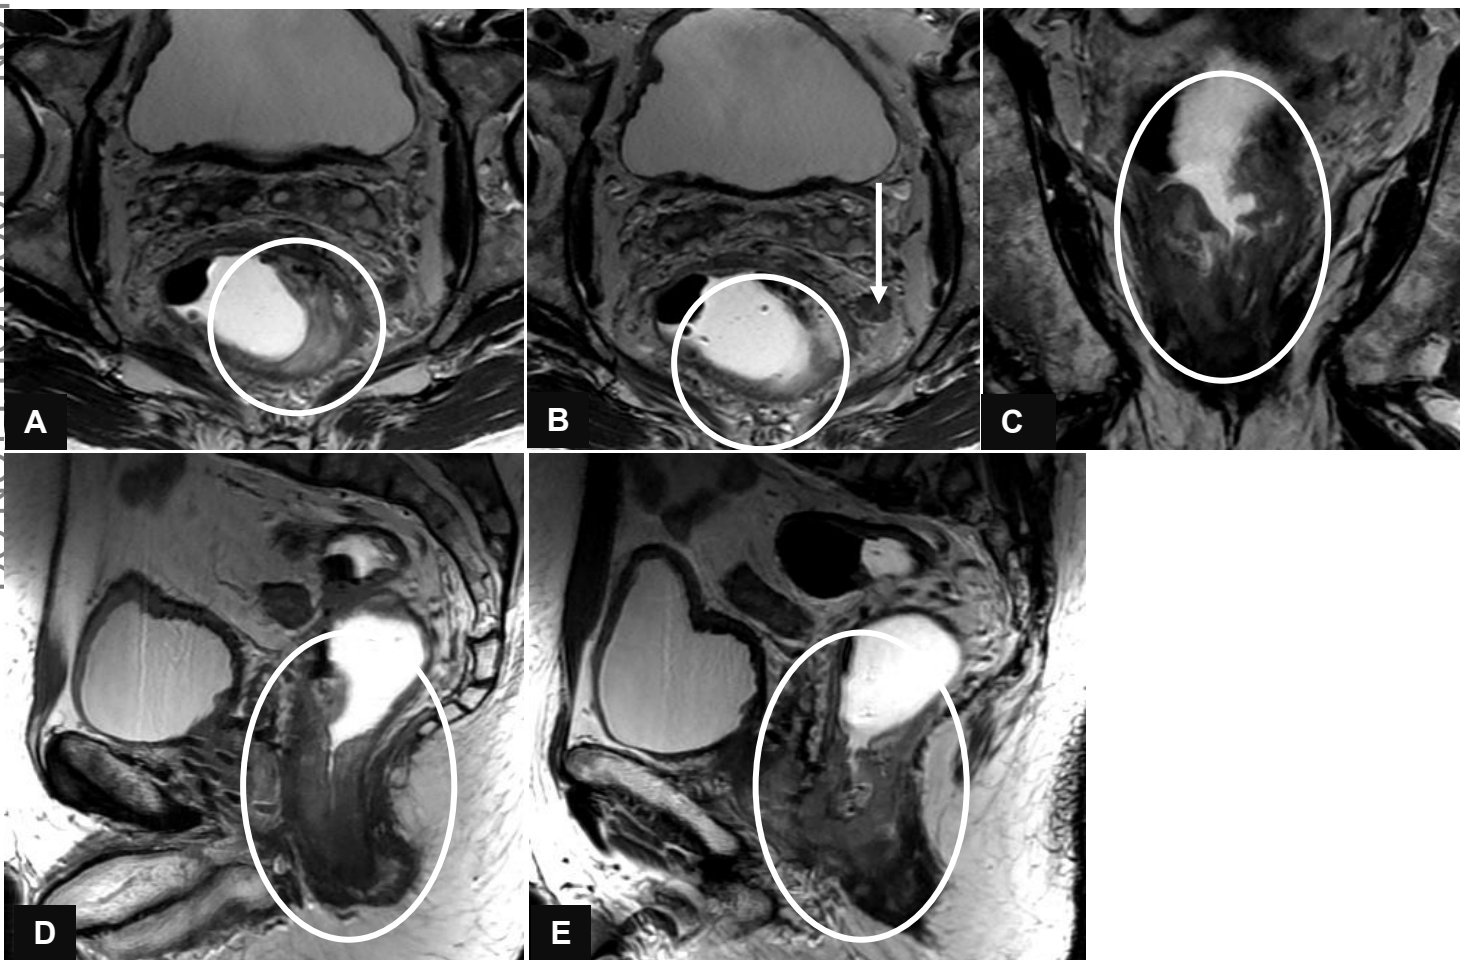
80-year-old male with known rectal cancer undergoing MRI for cancer staging. (A, B) Axial T2W images indicating a tumor in the left rectal wall (circles). (B) Arrow indicates a mesorectal lymph node. (C) Coronal T2W. (D, E) Sagittal T2W.
